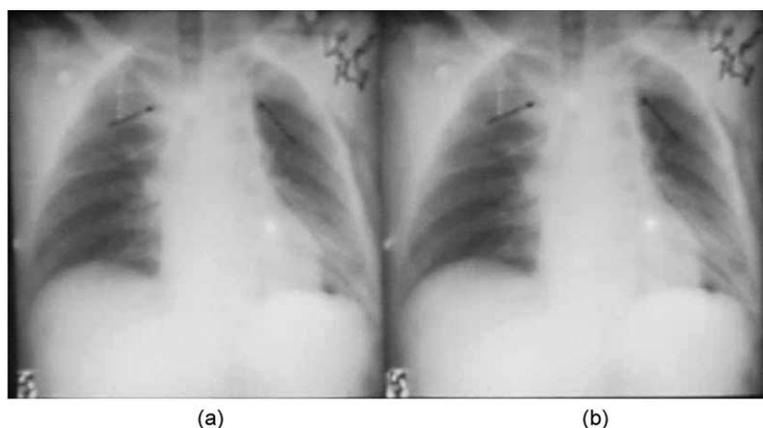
Result of interleaving DPCM error signal in the X-ray image: (a) original image; (b) interleaved image.
